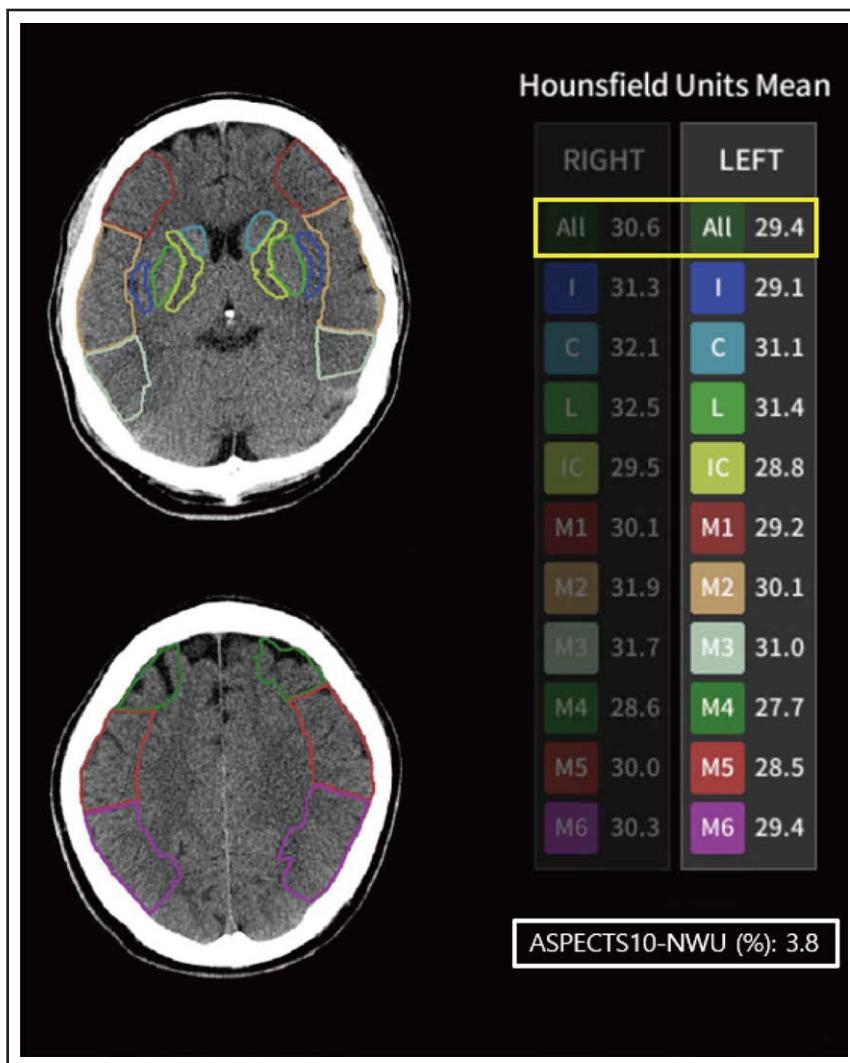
Quantification of Alberta Stroke Program Early Computed Tomography Score (ASPECTS) 10-net water uptake (NWU).
